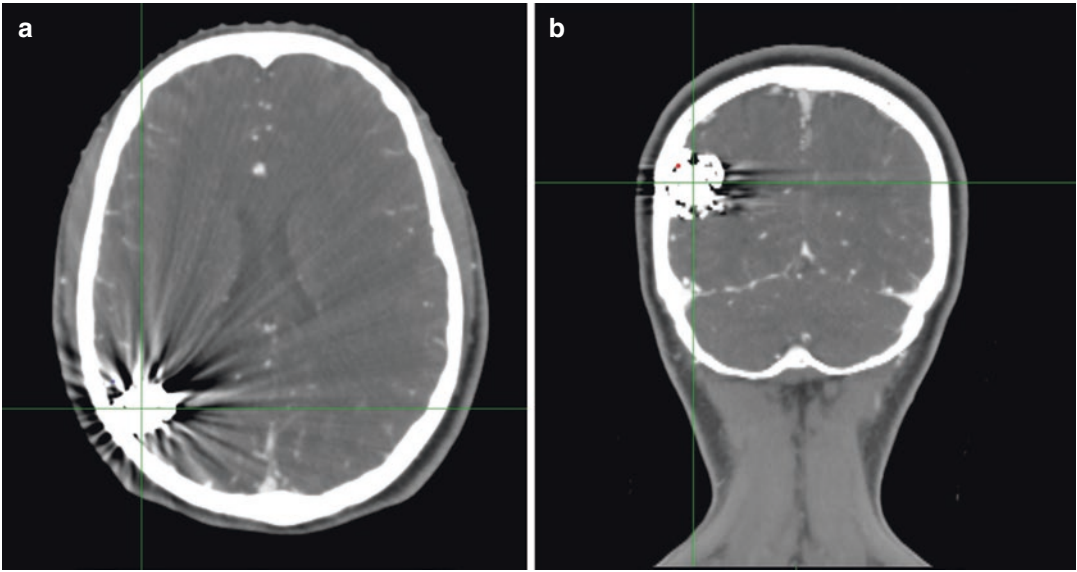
(a) Axial and (b) coronal slices of a CT image stack of a patient with embolized arteriovenous malformation. The emboli induce severe streaking artifact in and around the target. The density model cannot be directly
